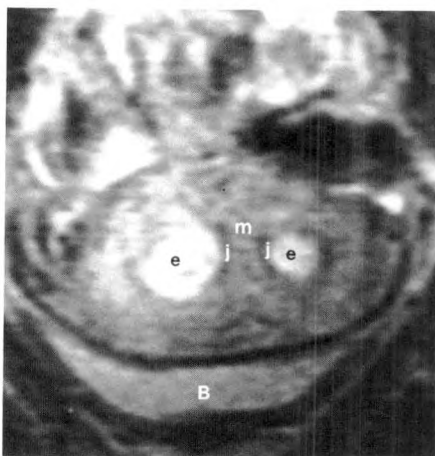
Coronal MR image (TR 2000 msec, TE 35 msec) showing septate uterus. e = endometrium, m = myometrium, s = septum, B = bladder.
